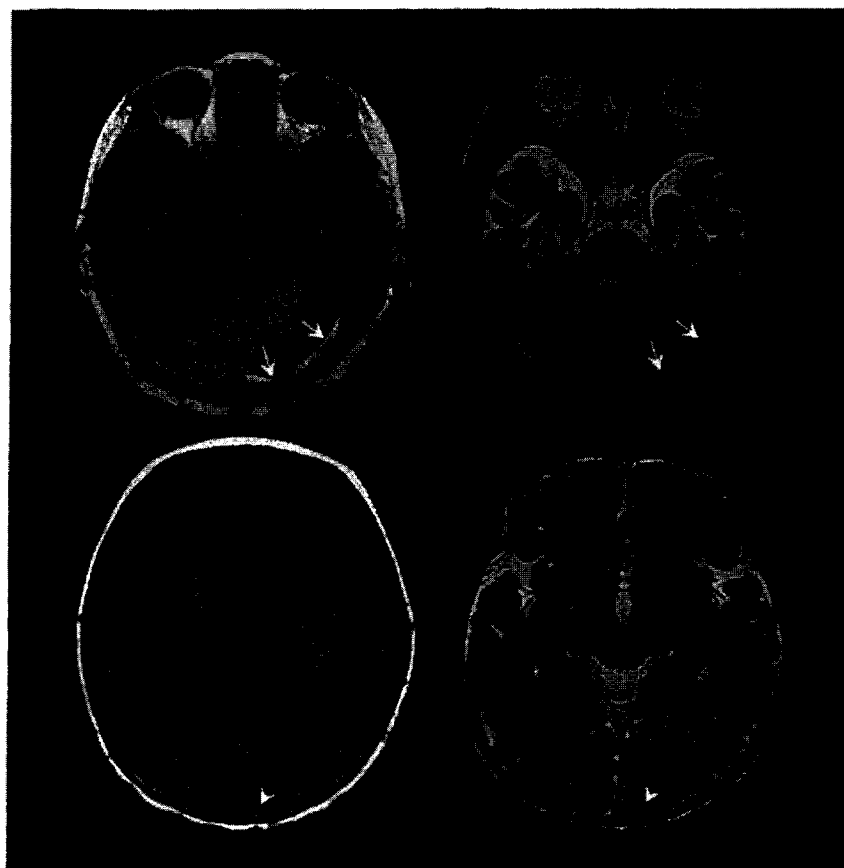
Images obtained from a 2-month-old female infant with left-side peritentorial and posterior interhemispheric subdural hemorrhage. Axial MRI images show T1-hyperintense and T2-hypointense sediment along the tentorium (top row, arrows) with T1- and T2-isohyperintense supernatant above (bottom row, arrowheads).
